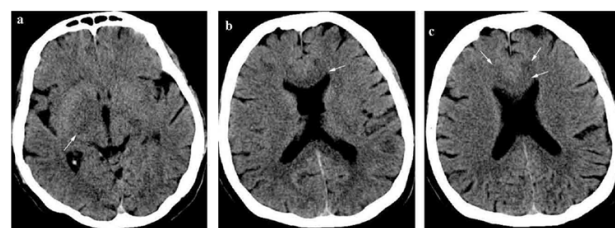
(a, b, c)-Unenhanced CT (October 15, 2012): Hypoattenuating areas involving the genu of corpus callosum and the right lenticulo-capsular region.
